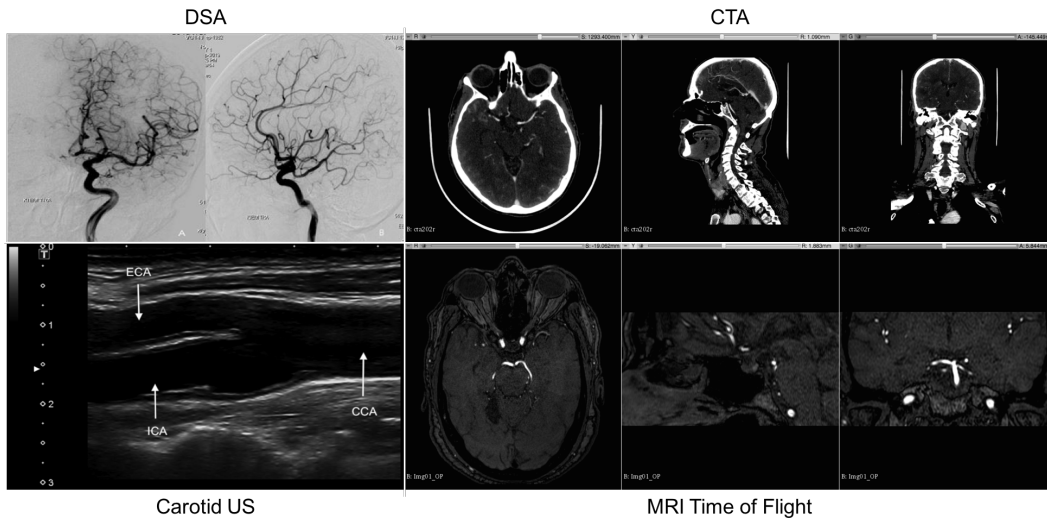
Common imaging modalities employed in cerebrovascular applications: from top to bottom, left to right, Digital Subtraction Angiography (DSA); axial, sagittal and coronal view of a Computed Tomography Angiography (CTA); Ultrasound (US) scan of the Common Carotid Artery (CCA) bifurcating into the External and Internal Carotid Artery, respectively ECA and ICA; three canonical orthogonal views of a cerebral MRI Time-of-Flight (TOF).
